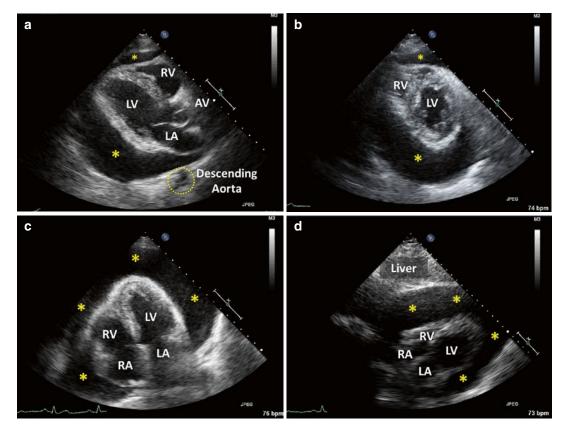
Pericardial effusion. Transthoracic echocardiogram demonstrates a large pericardial effusion (*asterisks*) in a 47-year-old woman with breast cancer. Panel a: Parasternal long axis view demonstrates typical interposition of the pericardial effusion (*asterisks*) between the heart and the descending thoracic aorta. This finding differentiates a pericardial effusion from a left pleural effusion in which there is no such interposition between the heart and the descending thoracic aorta. Panel b: Parasternal short axis at the level of the papillary muscles demonstrates that the pericardial effusion (*asterisks*) is larger posterior to the left ventricle that anterior to the right ventricle. This is due to gravity in this supine patient. Panel c: In the apical 4-chamber view, note that the pericardial effusion (*asterisks*) surrounds the cardiac apex. This feature helps distinguish a pericardial effusion from a pleural effusion. Panel d: Subcostal view demonstrates a large pericardial effusion (*asterisks*). Abbreviations: AV aortic valve, LA left atrium, LV left ventricle, RA right atrium, RV right ventricle symmetrical; a larger amount of fluid tends to occur in more dependent areas compared to less dependent ones. In a supine patient, circumferential pericardial effusions tend to be larger posterior to the left heart than anterior to the right heart. Loculated pericardial effusions may occur in any portion of the pericardial sac.
